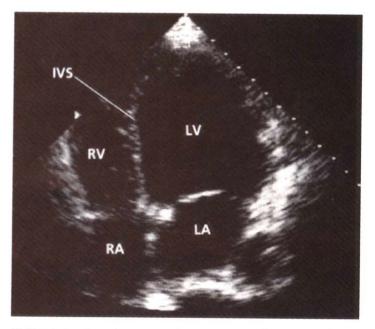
Two-dimensional echocardiographic study of a patient with dilated cardiomyopathy revealing four-chamber enlargement.
